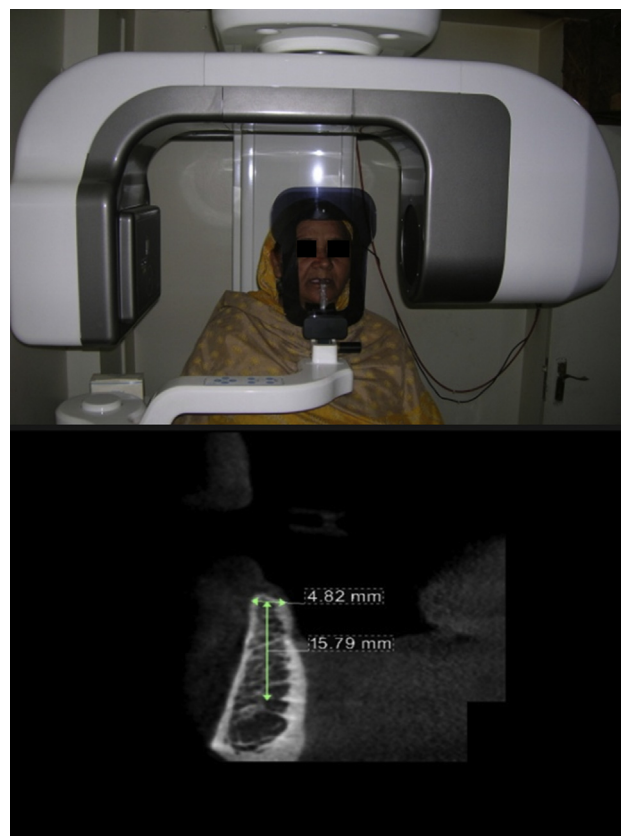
Cone beam CT evaluation.
